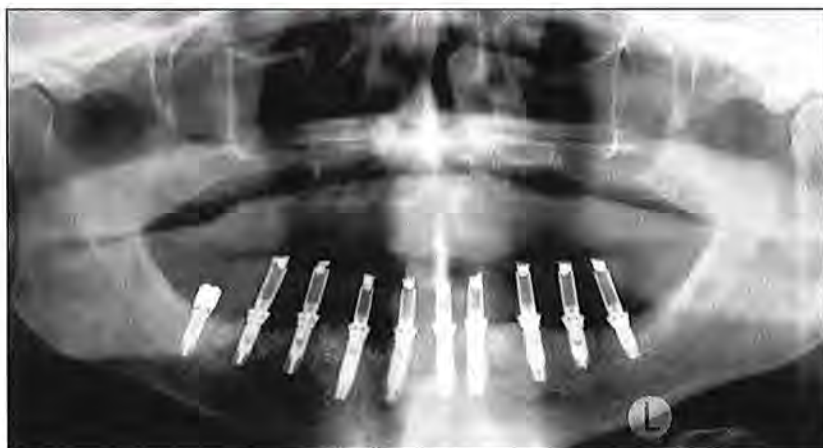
Radiograph following removal of the TIs. The restorative implants now support the fixed provisional prosthesis.
